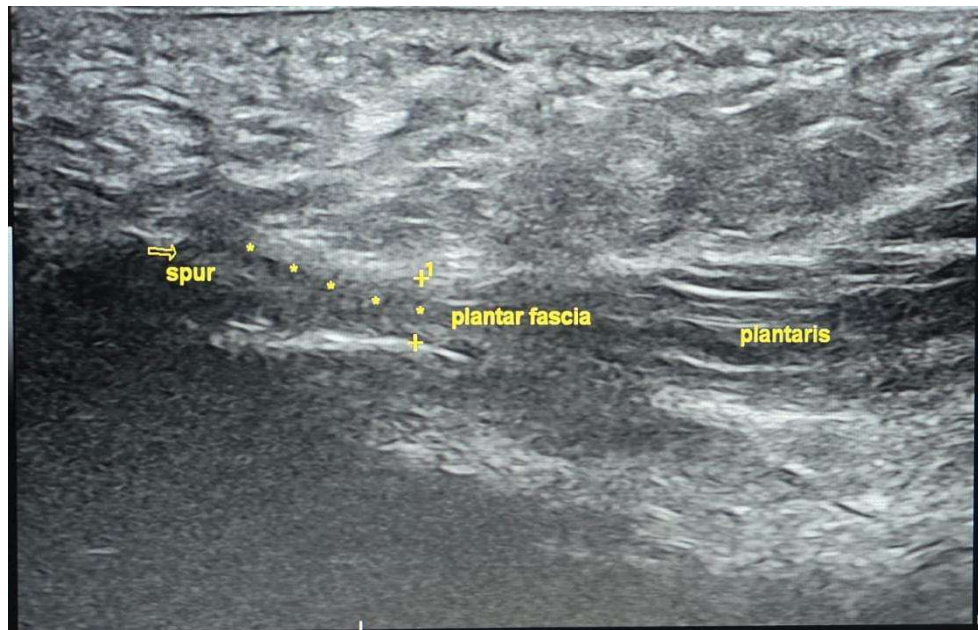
Before treatment, Ultrasound finding shows plantar fascia (PF) thickness as 4.0 mm on the Right side.
